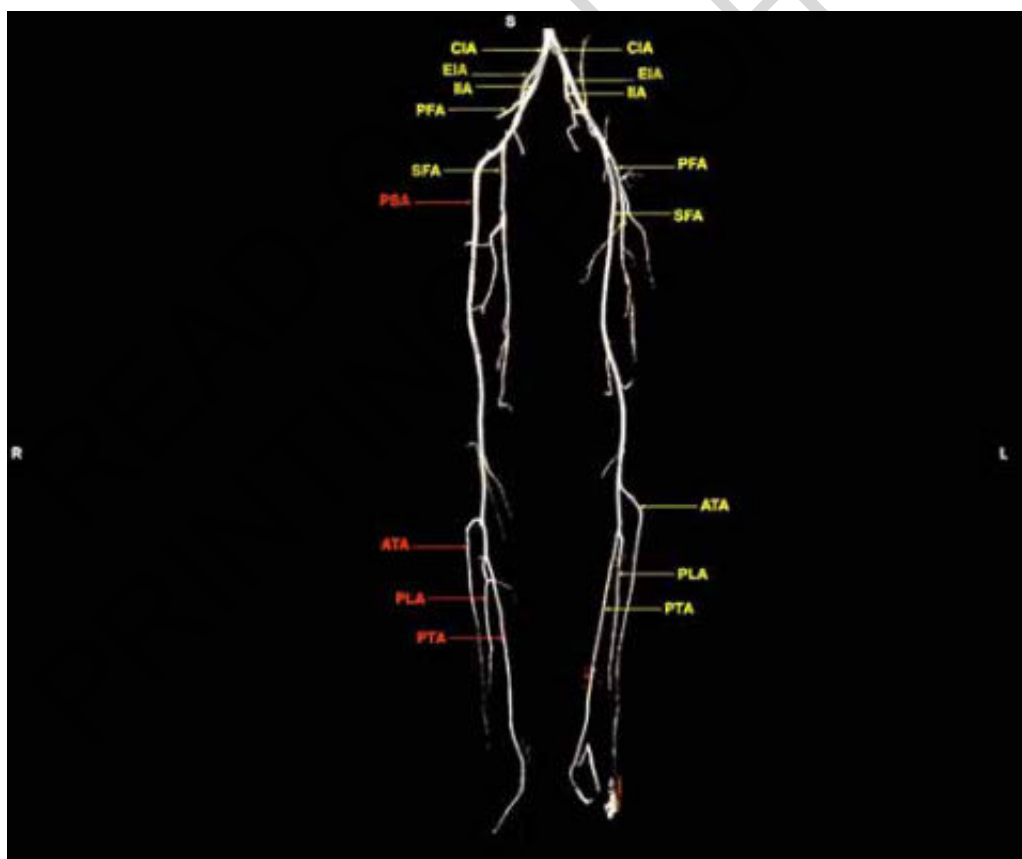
Postoperative CTA 3D reconstruction. On the right limb, course of PSA, arising from IIA, and its branches can be observed, with ATA, PLA and PTA derived from distal portion of PSA. Arterial bypass of SFA is still patent, while PFA has been ligated after tumor resection. On the left limb, usual vascular pattern of SFA system can be observed, compared to contralateral anomalous PSA pattern.
